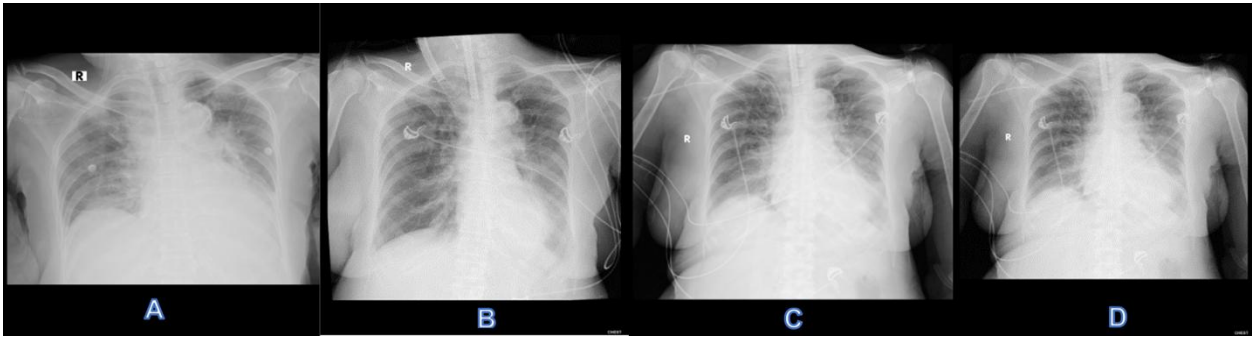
Radiological Evidence. The chest radiograph demonstrates bilateral pulmonary opacities consistent with ARDS. A: first day in ICU; B: Third day in ICU; C: 8th day in ICU; D: 11th day in ICU.
